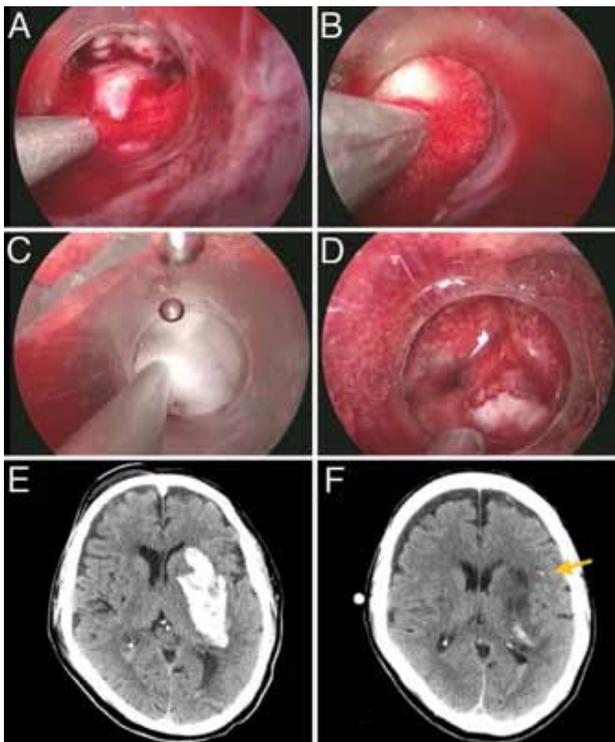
Using a hemostatic agent in a case of putaminal hemorrhage. A–D: Intraoperative images showing the use of the hemostatic agent. The bleeder is identified (A) and FloSeal is applied to bury and pack the bleeder and adjacent tissue (B). The bleeder is then covered with cotton and gentle pressure is applied with the suction tip while saline irrigation is performed (C). Hemostasis is achieved after 2 minutes (D), and saline irrigation is then used to wash out residual hemostatic agent. E: Preoperative axial CT scan showing the left putaminal ICH. F: Postoperative CT scan showing 5 ml of residual hematoma and the ICP monitor (arrow) that was inserted through the operation tract.
